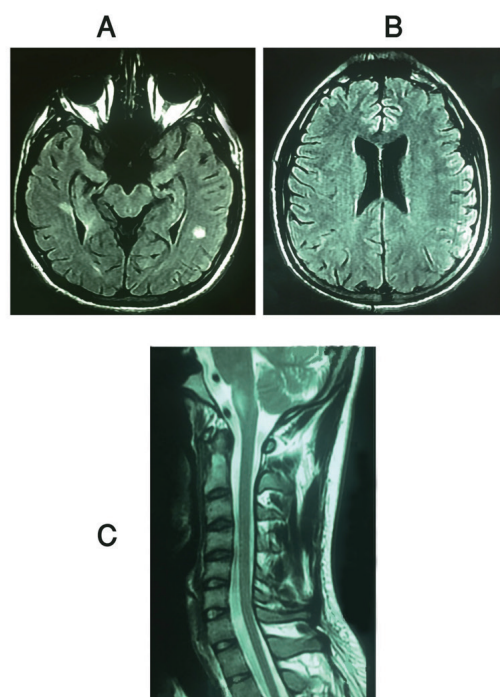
a, b, c. MRI revealed demyelinating plaques in the pons, and temporal and periventricular regions.
